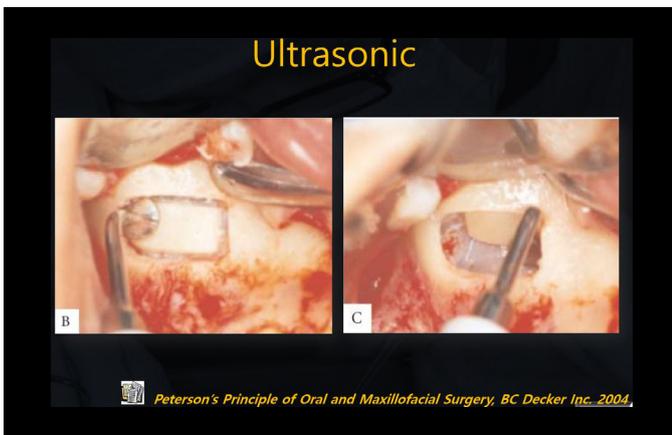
Osteotomy by Ultrasonic device
